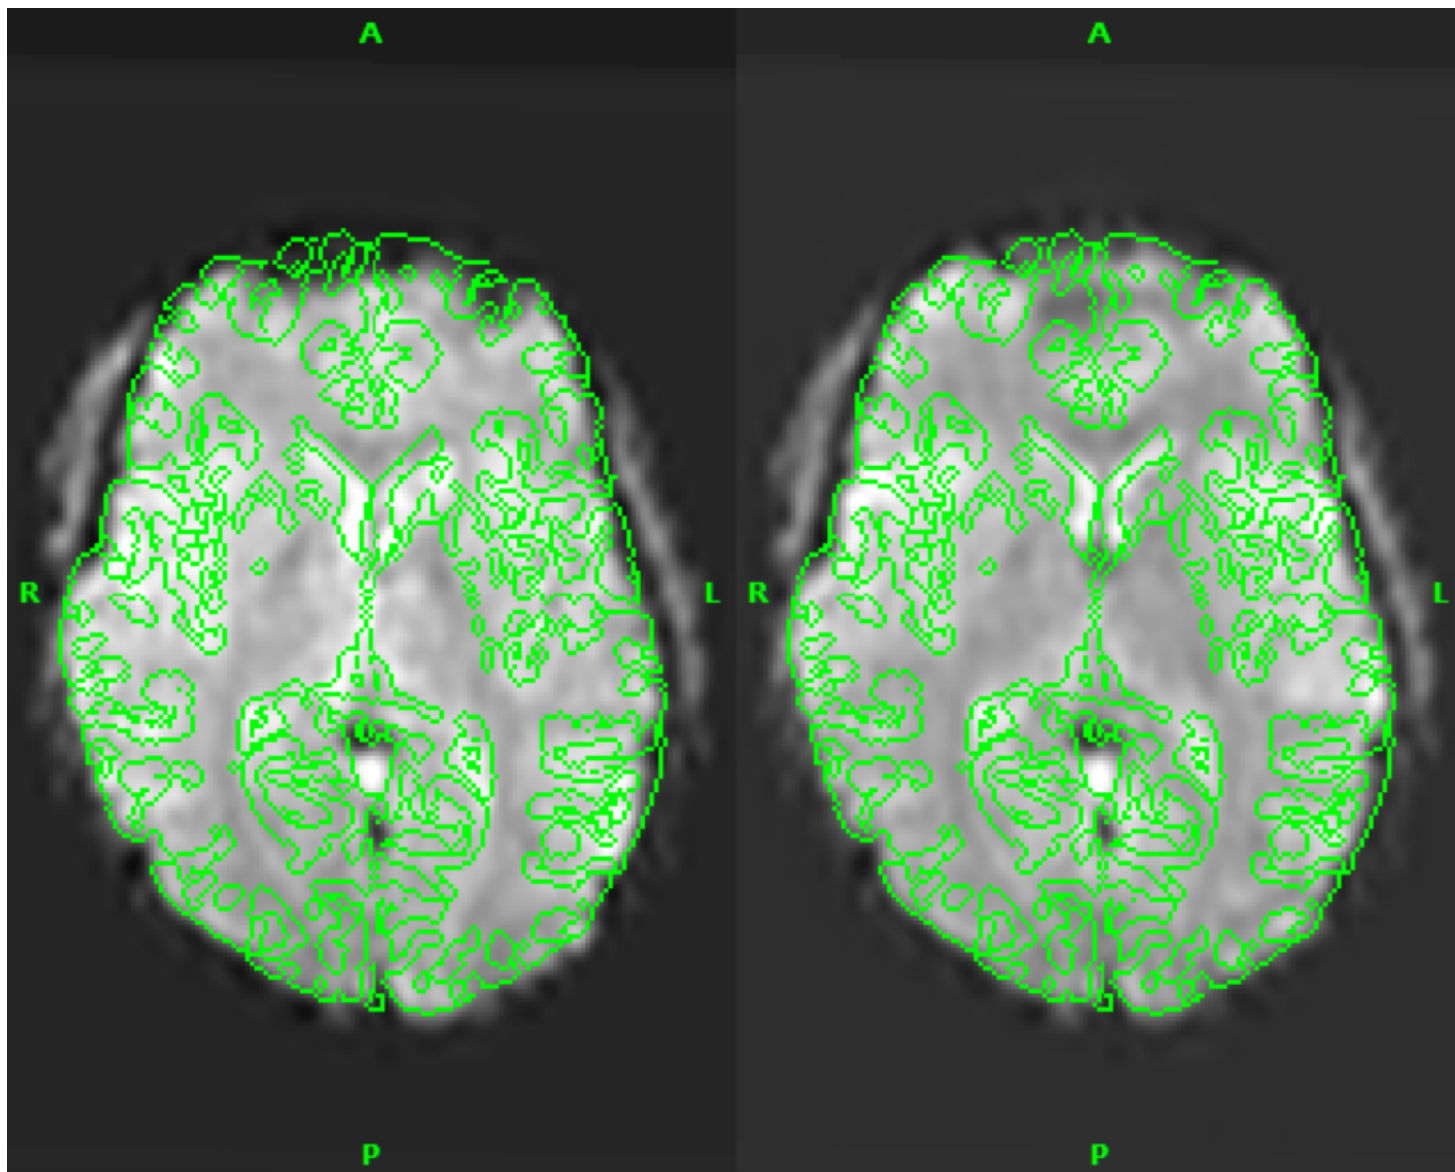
Comparison of (left) original EPI and (right) distortion corrected EPI relative to an edge map computed from the corresponding T1 MRI (green outline). The EPI volumes are shown resampled to the space of the T1 MRI.
